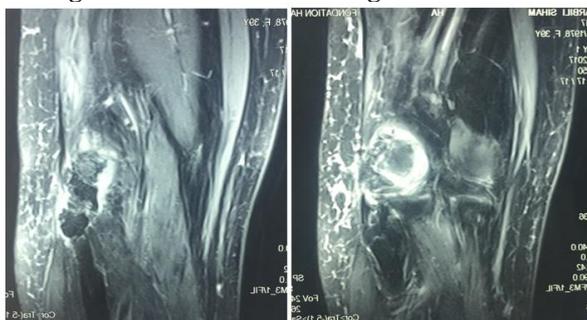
MRI of the knee showing Melorheostosis
